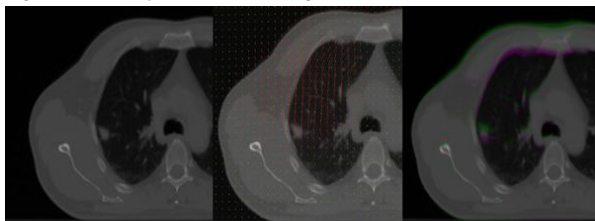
example of an adapted planning CT scan for a patient with a systematic baseline shift of 7.5 mm in the AP direction. Left: planning scan. Middle: average warping vector field derived from deformable registration of 3 initial CBCT scans. Right: Adapted scan in green with original scan overlay in magenta.
